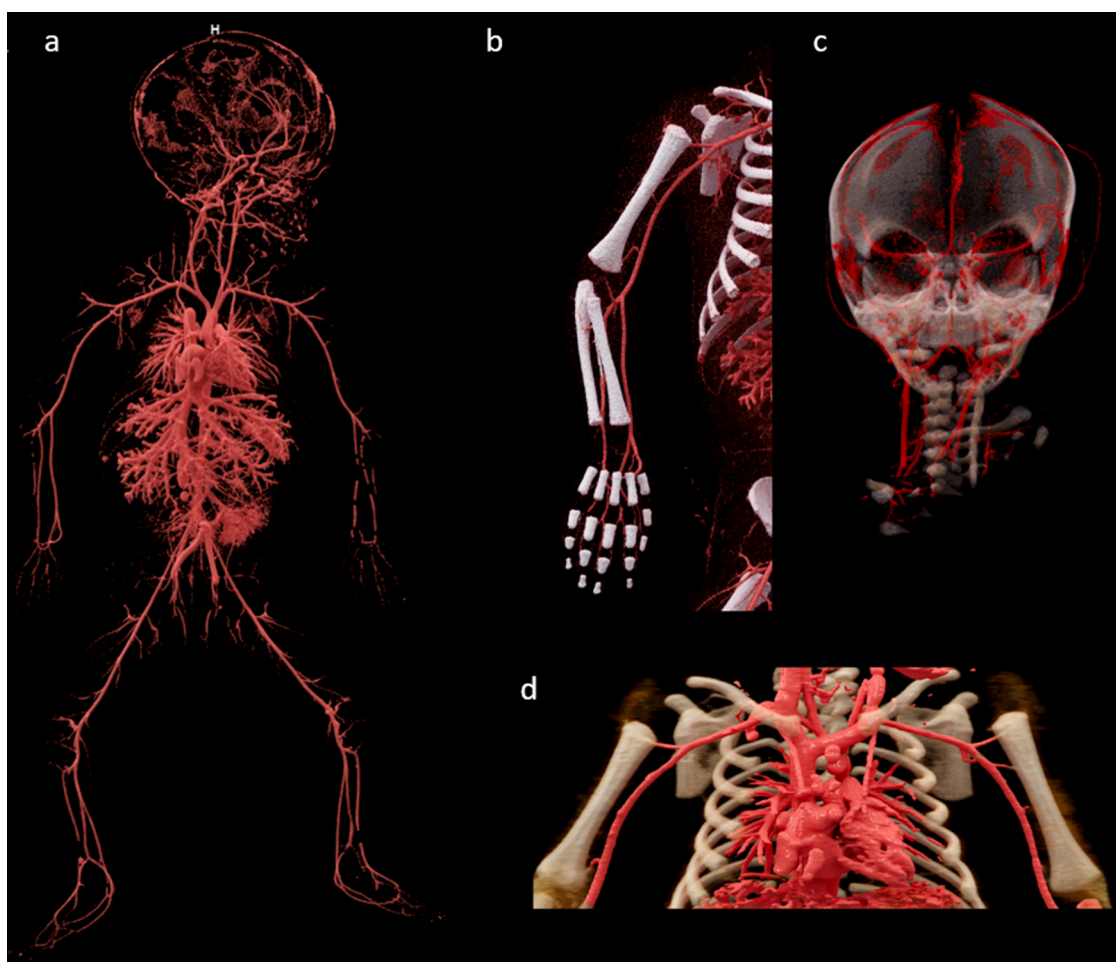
Fetus deceased at 175 days of gestational age. CT angiography image after injection of 7mL in the arterial system shows opacification of the entire arterial system using Cinematic Rendering Technique (CRT) (a) highlighting small arteries such as digital arteries (b) Willis circle (c) in anterior view. Venous opacification after injection of 15 mL optimizes cardiac chambers opacification (d).
